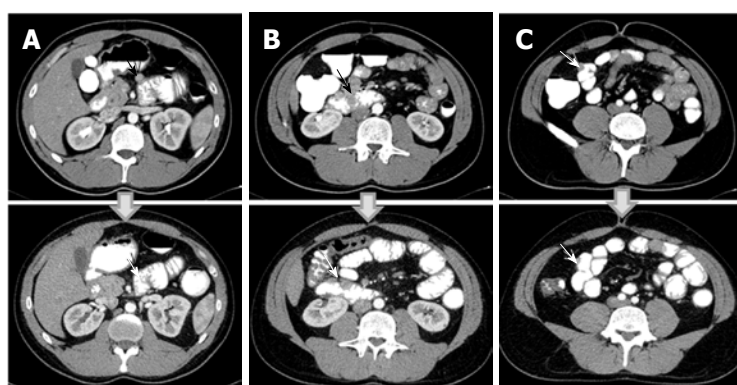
Imatinib response evaluation of the gastrointestinal stromal tumors using contrast-enhanced abdominal computerized tomography. Pre- and post-treatment CT images are shown on upper and lower series respectively. A partial response is seen in jejunal (A, B) and ileal (C) GISTs in the following 3 mo after imatinib therapy (arrows). CT: Computerized tomography; GIST: Gastrointestinal stromal tumors.
